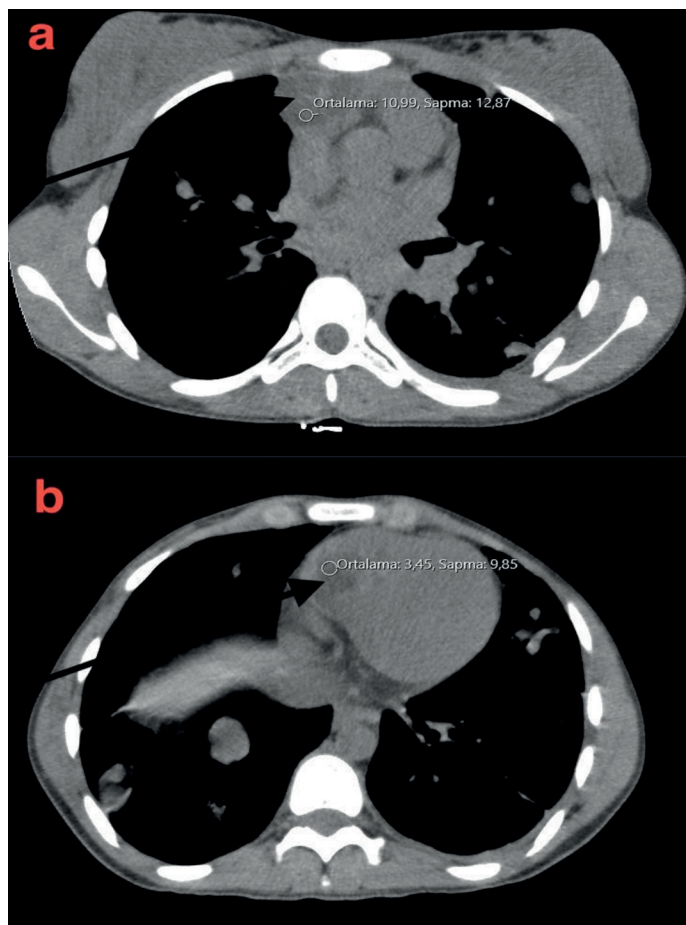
Unenhanced thorax CT
